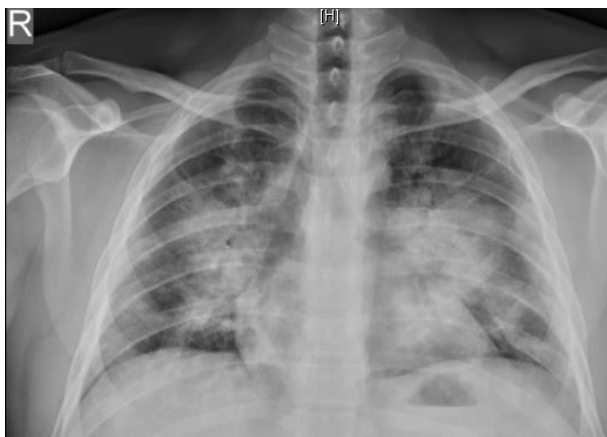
Chest radiograph showing features suggestive of acute respiratory distress syndrome
